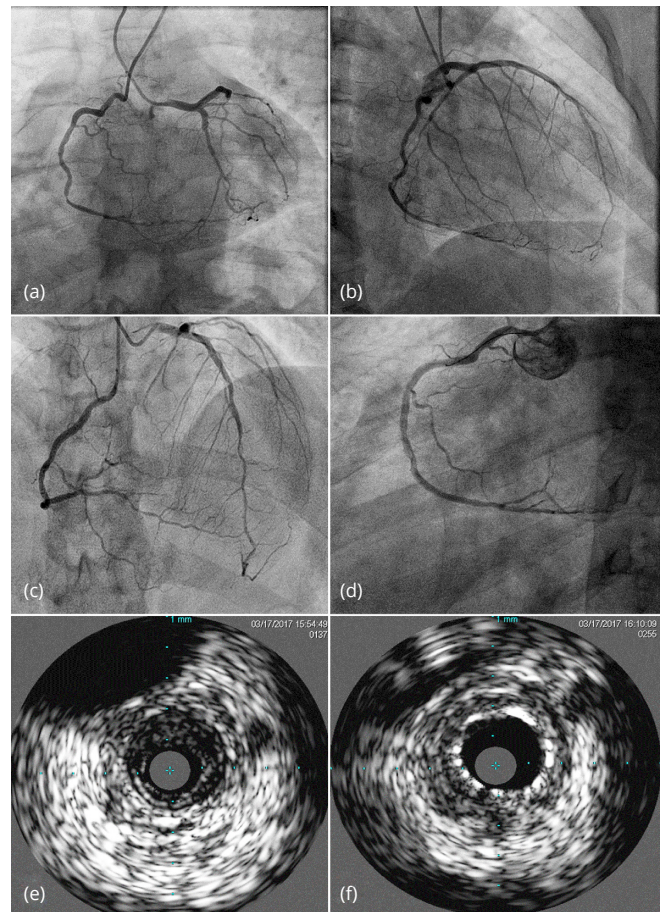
Low contrast approaches to Percutaneous Coronary Intervention (PCI) through simultaneous injection rotational angiography and Intravascular Ultrasound (IVUS). Detailed angiographic projections provided from rotational angiography at (a) Left Anterior Oblique Caudal; (b) Right Anterior Oblique Caudal; (c) Right Anterior Oblique Cranial angulation; Angiography of the right coronary artery post-stent (d); Intravascular ultrasound before (e) and after (f) deployment of a 2.75 x 12mm Xience (Abbott, USA) stent.
